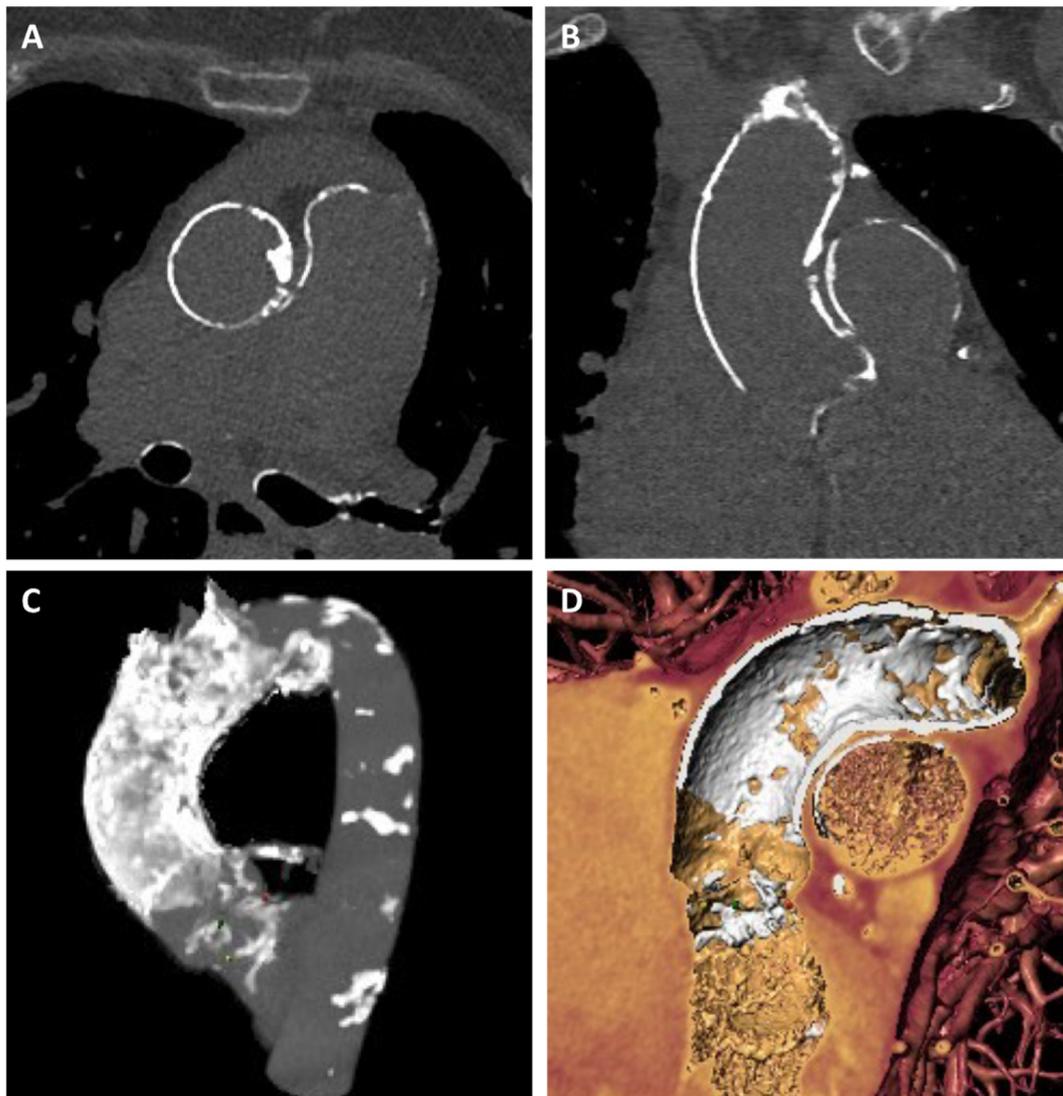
Multi-slice native computed tomography images of porcelain aorta. (A) Axial MPR, (B) coronal MPR, (C) MIP at LAO 45°, (D) Volume rendering. MIP = maximal intensity projection, MPR = multiplanar reformation.
